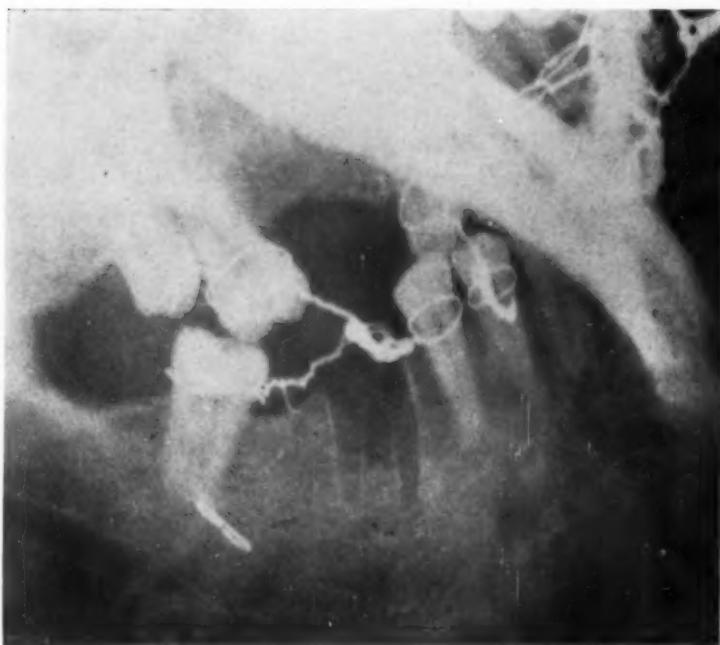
X-ray film of right jaw. The root has been removed and intermaxillary ligation applied.
